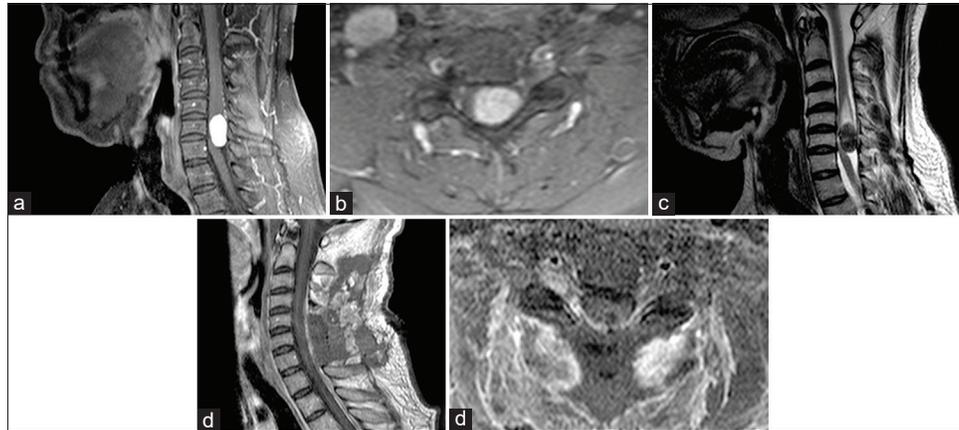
Sagittal (a) and axial (b) T1-weighted magnetic resonance image (T1WI) showing an intramedullary exophytic C5-C7 tumor with homogeneous gadolinium enhancement. (c) Slight heterogeneous aspect on T2-weighted images (predominantly hypointense with alternating smaller hyperintense areas). Sagittal (d) and axial (e) T1WI indicating complete removal of the tumor.
